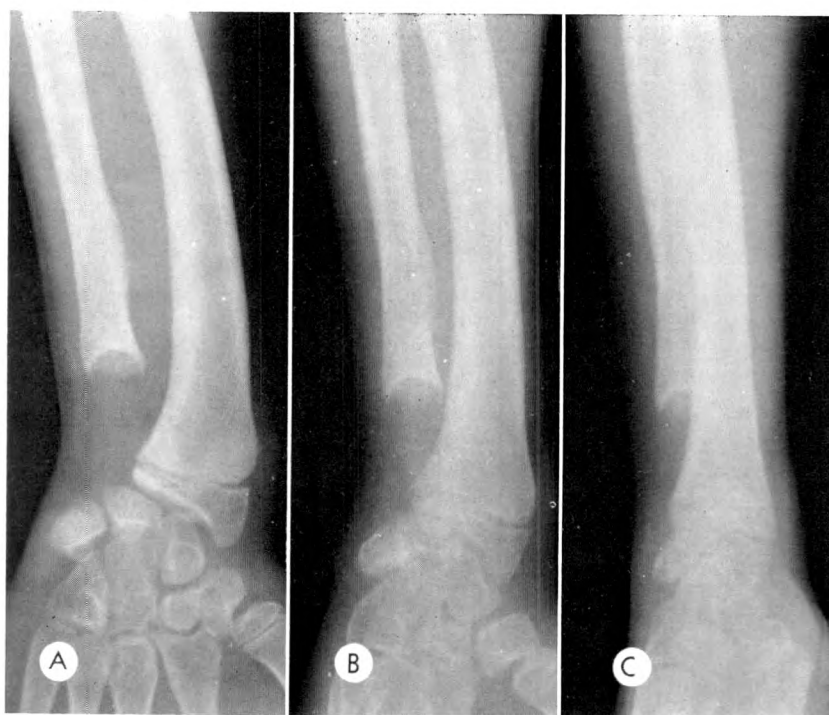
Case I. (A) Posteroanterior, (B) oblique and (C) lateral roentgenograms 8 years later show osteolysis of the distal portion of the shaft of the ulna and ulnar bowing of the distal radius.
